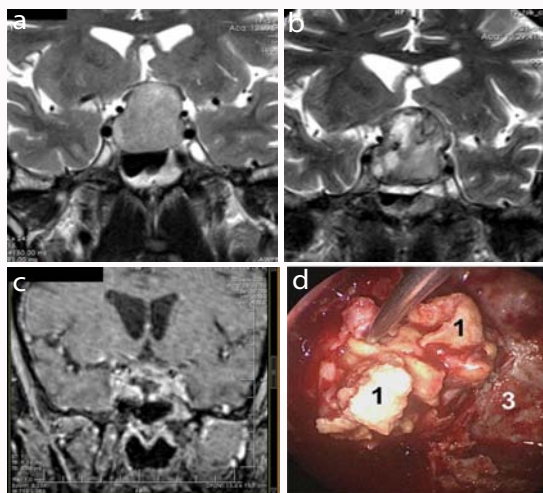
Clinical example of a typical pituitary apoplexy surgically treated one month after hemorrhage (the figure shows intraoperative and diagnostic images of a 56-year-old patient, 1.5 months after the onset of visual impairment: A) MRI reveals a typical pituitary tumor. 2 months after diagnosis, typical clinical manifestations of pituitary apoplexy appeared - acute headache, nausea, vomiting, and a rapid decrease in vision. The patient was hospitalized to the clinic a month after the deterioration of his condition with bilateral amaurosis. B) MRI data showed an increase in the size of the tumor, its stroma became heterogeneous, and edema of the mucous membrane of the sphenoid sinus appeared. C) MRI data 2 months after surgery shows complete tumor removal. In the neurological status after the operation, the appearance of light perception in the right eye was noted, with the preservation of amaurosis on the left. Electric stimulation of the optic nerves did not provide further positive dynamics). D) The tumor was then removed by transnasal access. During surgery, the tumor was seen to be atypical for a pituitary tumor, yellow in color, dense, with difficulty separated from the dura mater.
